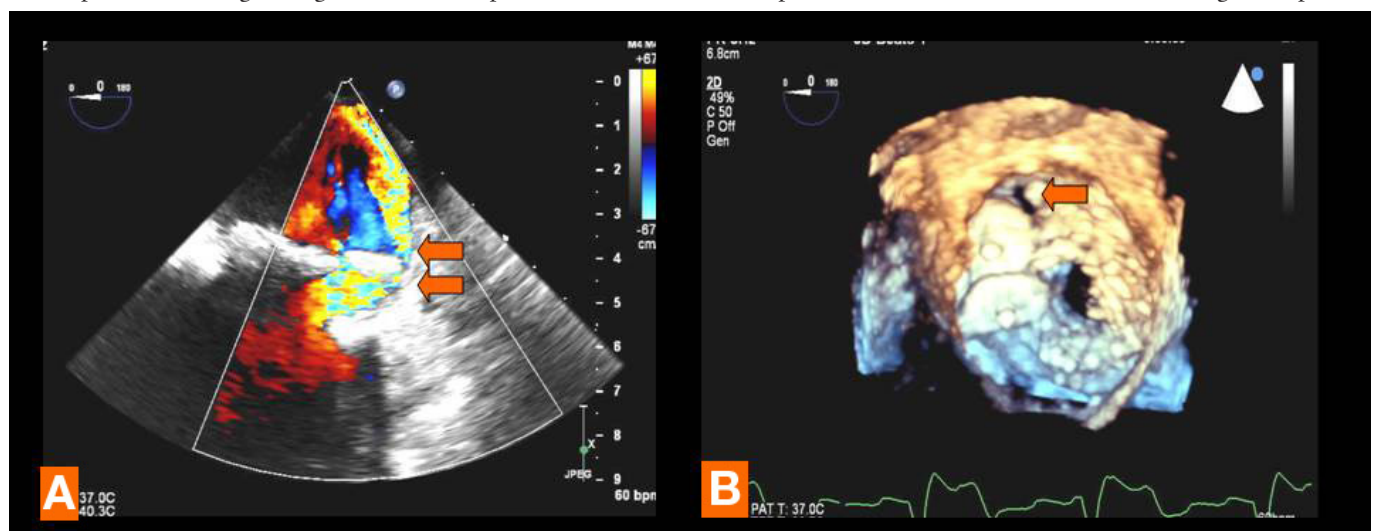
A, Color Doppler transesophageal echocardiogram (TEE) shows the eccentric high-velocity paravalvular jets (orange arrows) after device deployment. B, Three-dimensional TEE view from the same patient showing the residual space (orange arrow) after the Amplatzer deployment.
